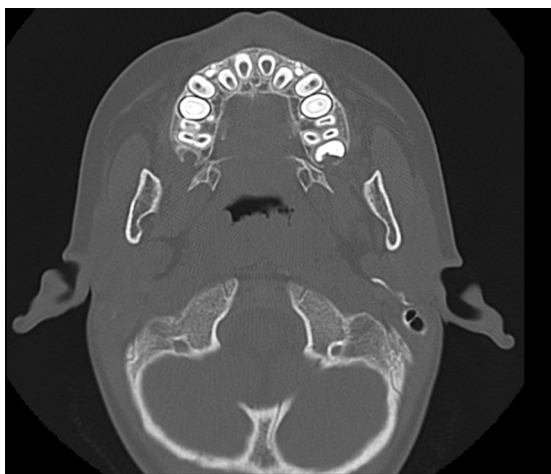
Computed tomography image. No bone resorption and destruction were observed in the upper deciduous central incisor area.
